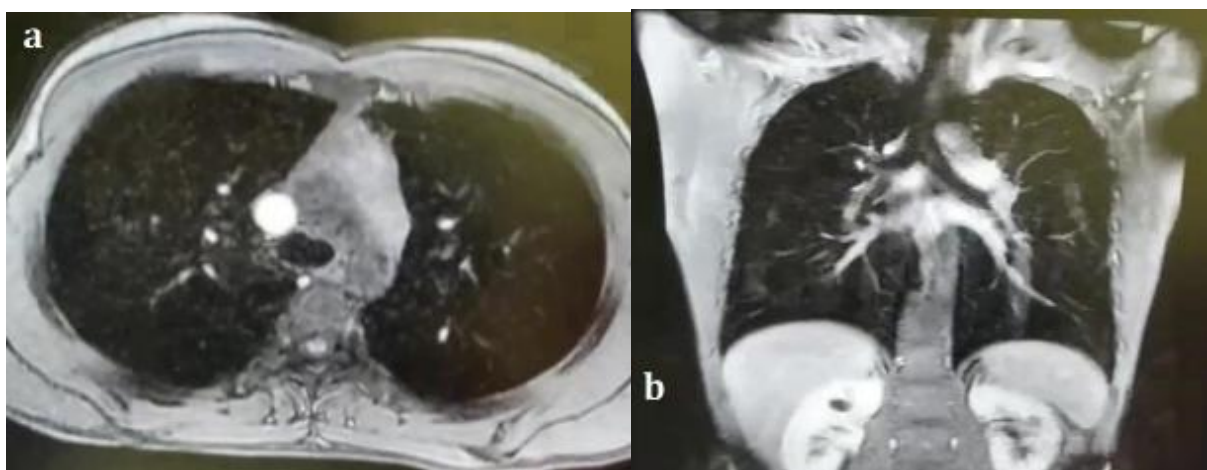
Thoracic magnetic resonance imaging (MRI) demonstrating a large anterior mediastinal mass with irregular margins and close proximity to major mediastinal vascular structures. Axial (A) and coronal (B) views are shown
